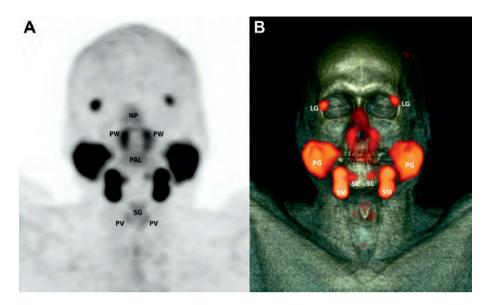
PSMA PET/CT of the head and neck with healthy salivary glands. Coronal maximum intensity projection of normal PSMA distribution in a 60-year-old male with no history of disease in the head and neck, who was scanned for staging of prostate cancer using PET (A) in combination with CT (B). NP = nasal and nasopharyngeal mucosa; PW = posterior pharyngeal wall; PAL = soft palate; SG = supraglottic larynx; PV = plica vocalis; LG = lacrimal gland; PG = parotid gland; SM = submandibular gland; SL = sublingual gland.
